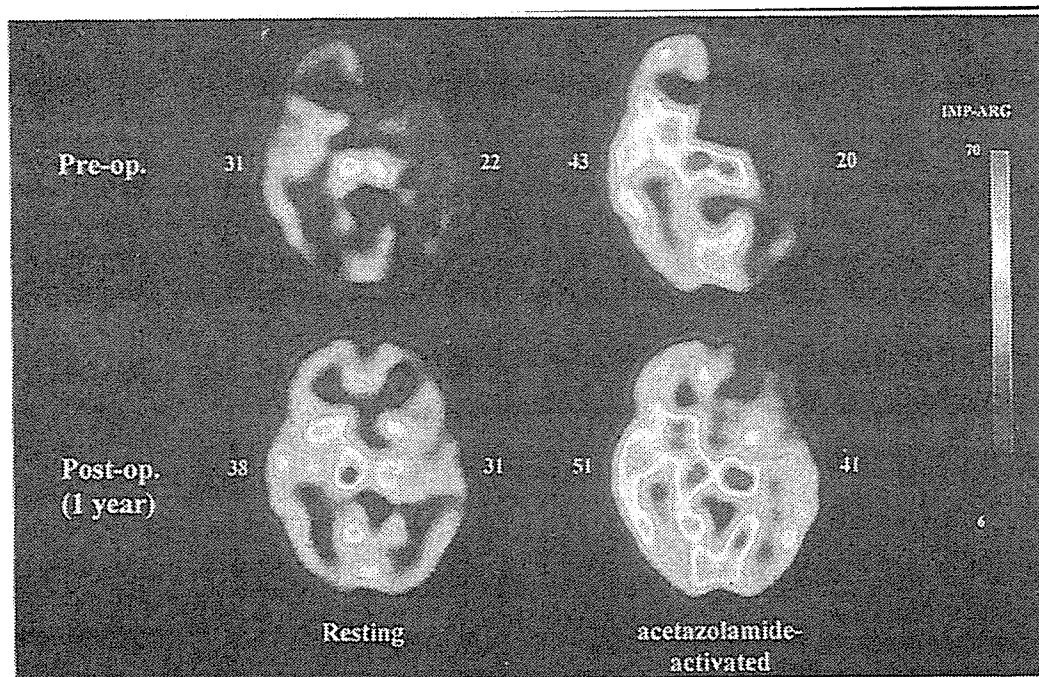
血行力学的脳虚血症例の脳血流 SPECT 定量画像解析
